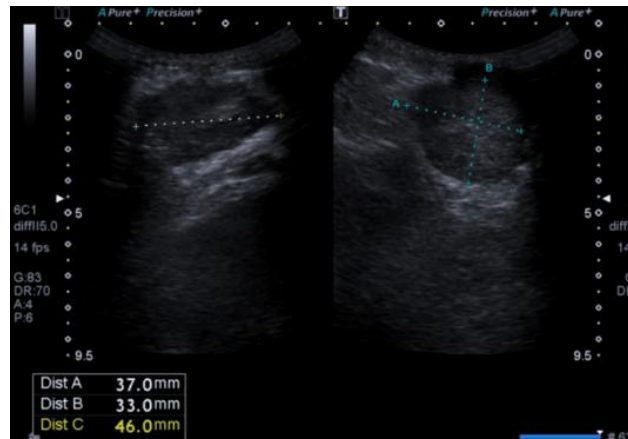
Breast ultrasound. The figure shows an hypogenic mass measuring 46mm with irregular margins.
